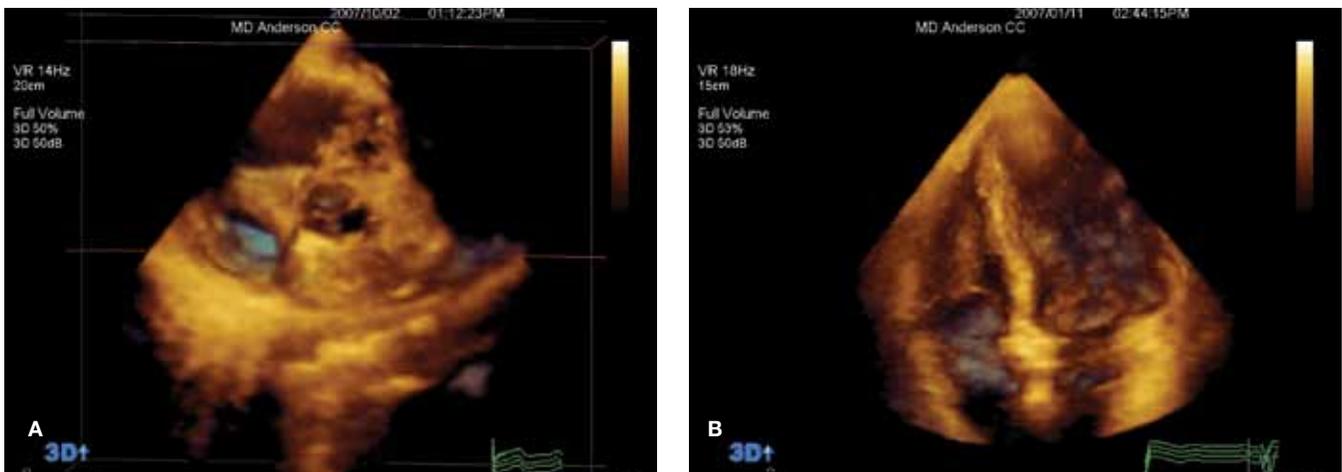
(A) Full-volume acquisition obtained from the short axis view of the patient with osteosarcoma shown in Figures 2 and 3. The mass was not amenable for surgical resection as it involved the aortic root. (B) Full-volume acquisition obtained from the apical 4-chamber view of a 60-year-old male with metastatic squamous cell carcinoma of the penis. The mass was not thought to involve the tricuspid valve after 2D-TTE evaluation; however, follow-up RT3DE revealed involvement of the tricuspid valve.
